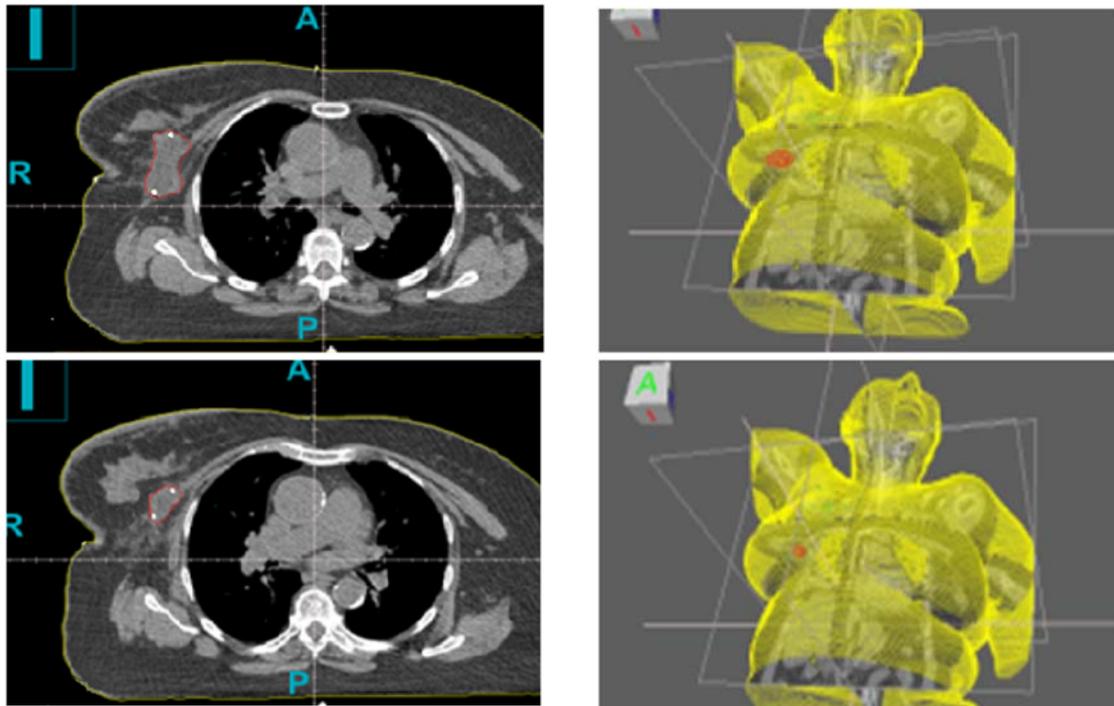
Delineation of the excision cavity on primary CT- scan before whole breast RT for one patient (upper figures). Delineation of the excision cavity on secondary CT- scan after whole breast RT (lower figures) for the same patient.
